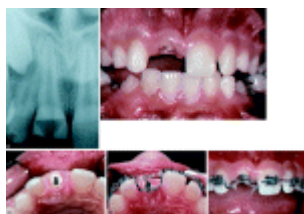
Crown-root fracture treated by orthodontic extrusion. Radiograph of the traumatized tooth (A). Clinical view after removal of fragments and extirpation of the pulp (B). A titanium post was cemented into the root (C), which provided the anchorage necessary for orthodontic extrusion (D and E).
